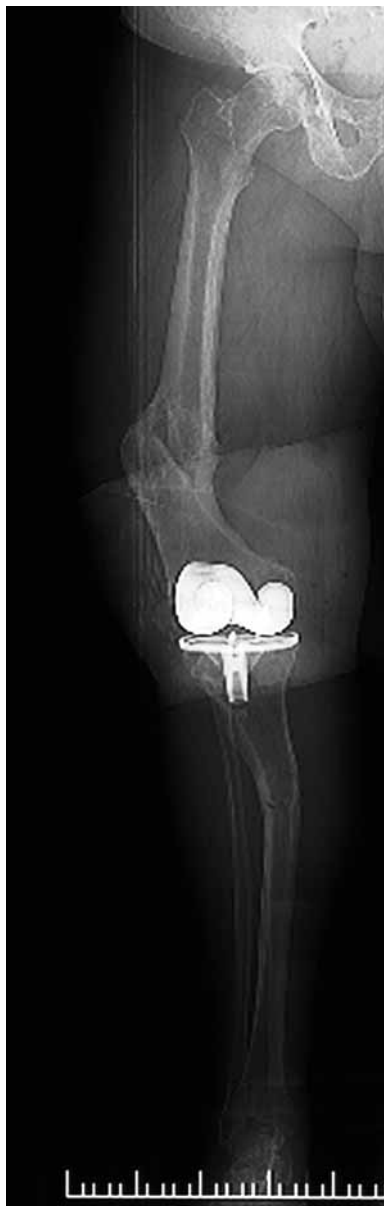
Right lower limb, postoperative AP radiograph.
